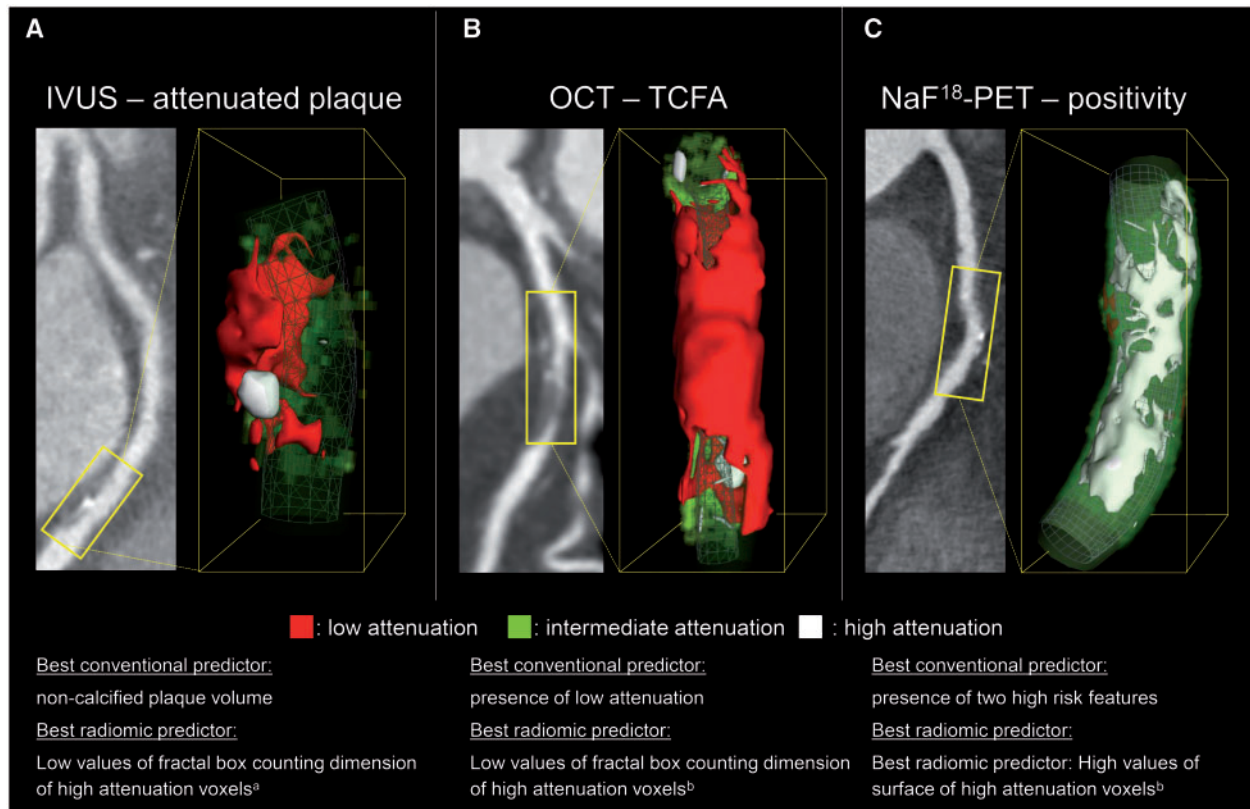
Representative curved multiplanar and volume rendered CT images of three coronary plaques corresponding to specific invasive and radionuclide imaging markers of plaque vulnerability. (A) A coronary lesion which scored the lowest on fractal box counting dimension of high attenuation voxels (component 30 when discretizing to 32 equally sized bins) which was indicative of attenuated plaque on IVUS [AUC: 0.72 (0.65–0.78)]. (B) Depicts a coronary plaque which scored the lowest on fractal box counting dimension of high attenuation voxels (component 8 when discretizing to eight equally sized bins) which was suggestive of OCT-TCFA [AUC: 0.80 (0.72–0.88)]. (C) A coronary lesion which had a high surface of high attenuation voxels (component 8 when discretizing to eight equally sized bins) which was the best parameter to identify NaF¹⁸-PET positivity [AUC: 0.87 (0.82–0.91)]. AUC, area under the curve; IVUS, intravascular ultrasound; NaF¹⁸-PET, NaF¹⁸-positron emission tomography; OCT-TCFA, optical coherence tomography identified thin-cap fibroatheroma. ^aComponent 30 when discretizing to 32 equally sized bins. ^bComponent 8 when discretizing to eight equally sized bins.
